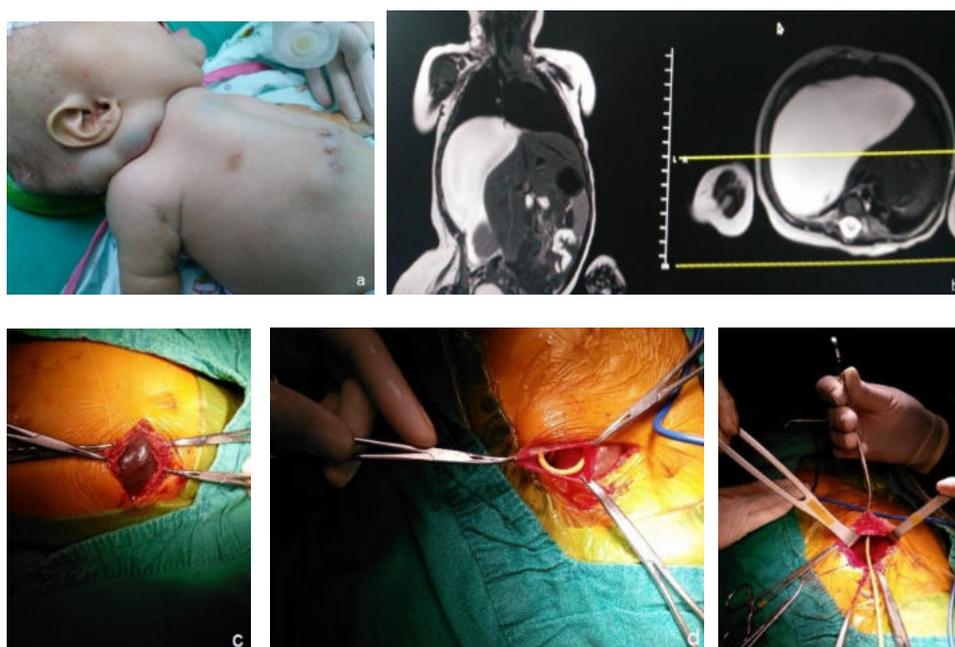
(a) Preoperative view showed swelling along the shunt, (b) The MRI planning indicate intra-abdominal cystic lesion, (c) Laparotomy performed by median incision and (d and e) VP shunt catheter, placed subserosal cystic lesion.
